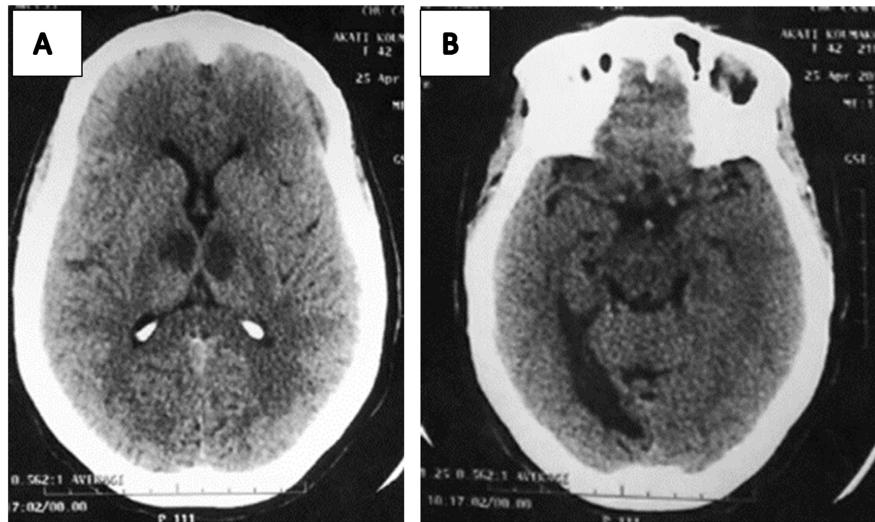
Brain CT at 48 hours showing bithalamic hypodensities involving the anterior and paramedian territories (A), and a right temporo-occipital porencephalic cavity (B) compatible with a chronic infarct in the superficial posterior cerebral artery (PCA) territory.
